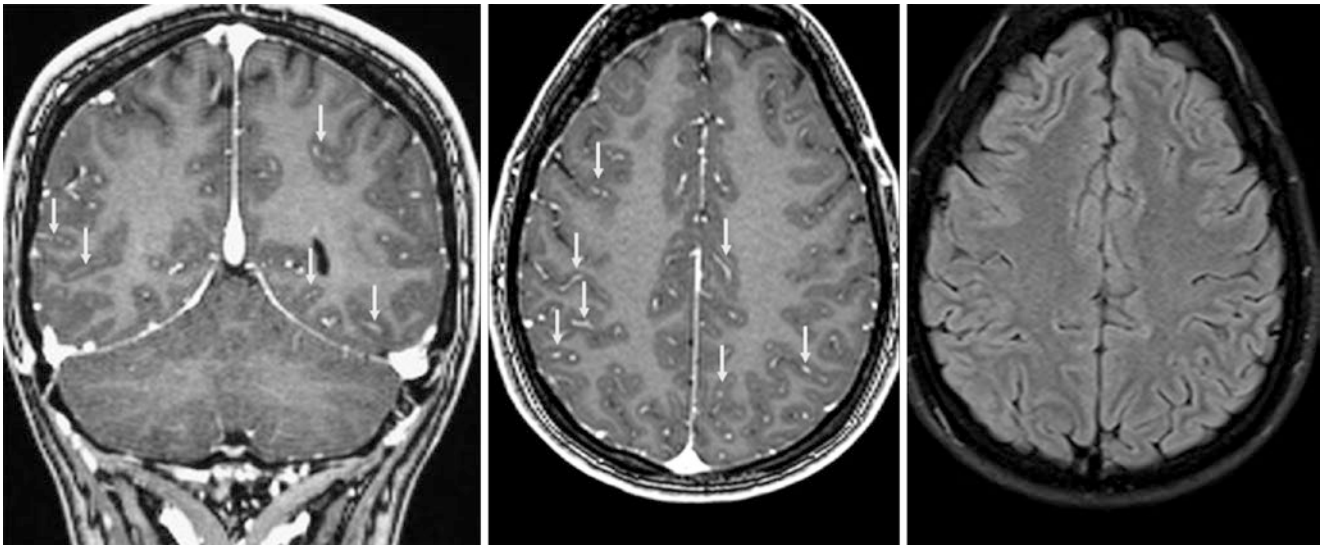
A 24 year old with chronic headaches and memory loss had a 1.5T MRI (without sedation) with CEMRI coronal (*left*) and axial (*middle*) GET1WIs that showed mild pseudo-LMCE (*arrows*), initially
